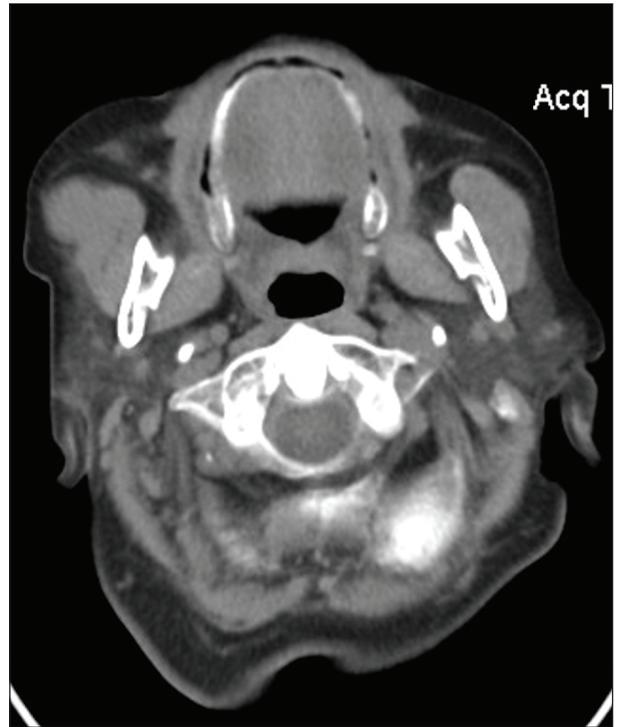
CT shows a rounded lesion at the level of the anterior margin of the right maxillary muscle
